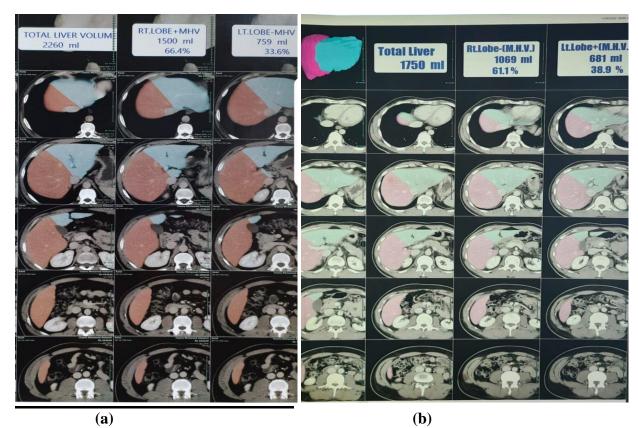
liver volume by CT volumetry; picture (a): showing liver volume before IGB placement measuring 2260cm³, picture (b): showing liver volume of the same patient measuring 1750cm³ after IGB placement.
